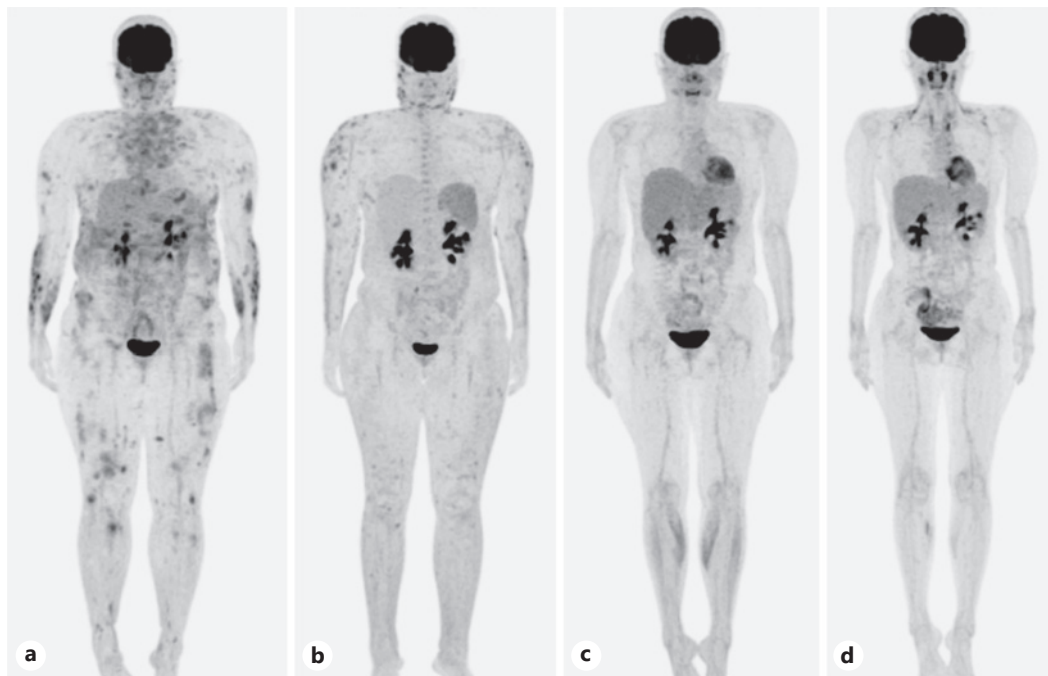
Our patient's PET/CT response to each treatment modality is shown. Her pretreatment PET-CT is shown in (a) followed by that after CHOP, BV, and EPOCH chemotherapy in (b); after six cycles of romidepsin in (c); and 6 months after allo-HCT in (d). PET/CT before treatment (a) and after chemotherapy (b) showed diffuse abnormal accumulation in subcutaneous adipose tissue. After romidepsin, the accumulation disappeared (c), and a CMR was maintained after allo-HCT (d). PET-CT, positron emission tomography/computed tomography.
